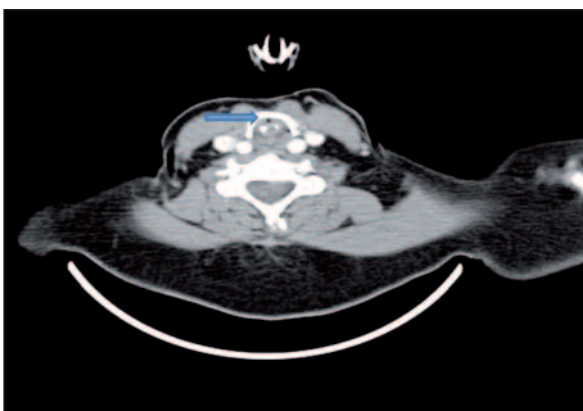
Computed tomography image of the rima glottis.
